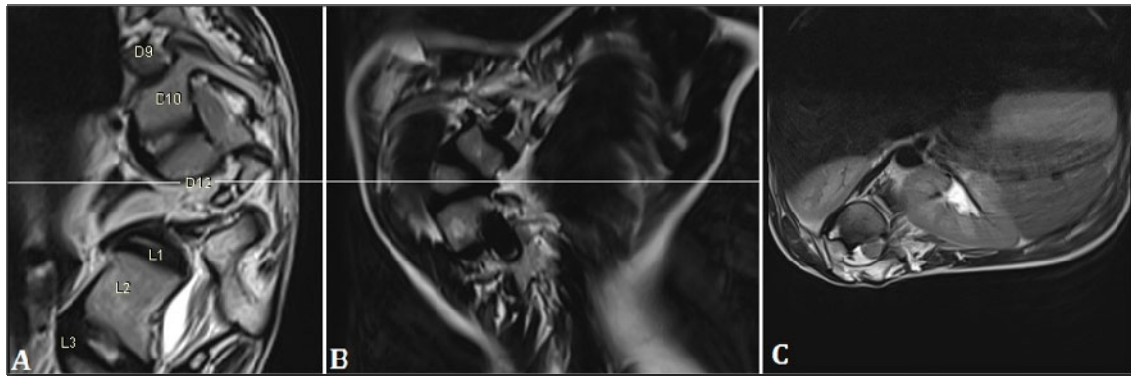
Preoperative serial Magnetic Resonance Imaging saggital view (A), coronal view (B) and axial view (C) of spine showing kyphoscoliotic deformity with right sided convexity (line drawn at D12 level).
